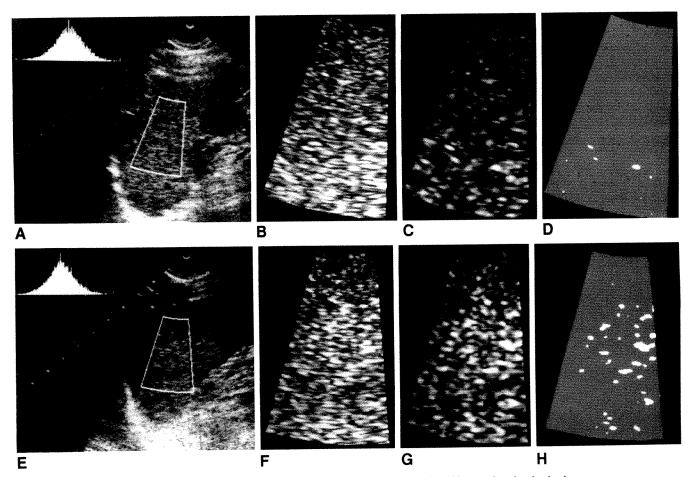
A, Image seen by operator during acquisition of ultrasonic waveform data from a region of interest in uninvolved spleen.
